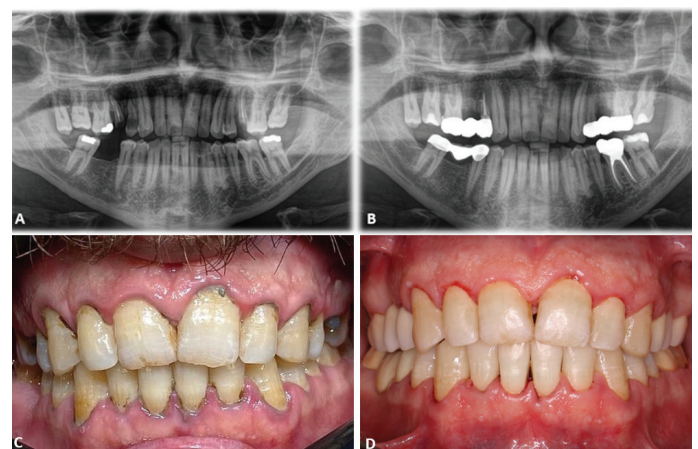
(A): Preoperative X-ray (B): Postoperative X-ray (C): Preoperative clinical photograph (D): Postoperative clinical photograph
